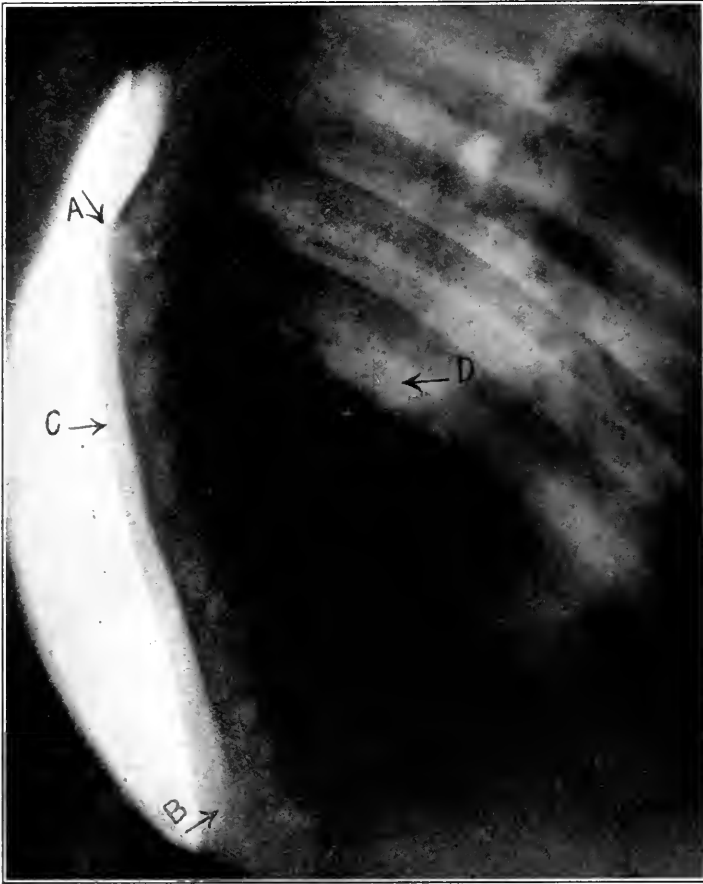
Roentgenogram, showing bone-graft fixation of spine for Pott's disease in case of a child aged five years. This case, seen by the author in consultation with T. Halsted Myers, proved to be one of the most acute cases of tuberculosis of the spine that the author has ever seen. The patient had been under the care of a very excellent orthopaedic surgeon who had not succeeded in controlling the symptoms by any known conservative means, such as plaster jackets, spinal braces, Bradford frames, etc. For some months the child had been immobilized by a well-fitted spinal brace (Taylor's), supplemented by recumbency in the dorsal position upon a Bradford frame. In spite of this most rigorous treatment, however, active symptoms had continued uncontrolled, with periodical attacks of violent vomiting which was apparently a reflex phenomenon resulting from the uncontrolled spinal condition. This seemed all the more certain after the more adequate spinal fixation by bone graft later, when the attacks of vomiting subsided entirely. The classical operation of Albee for the treatment of Pott's disease was performed by the author, the bone graft (indicated by arrows, A-B) being taken from the child's left tibia. Following operation, the patient made a very splendid convalescence, although the acuteness of the symptoms demanded great conservatism. The child was kept in the recumbent position in bed for about three months, followed by an application of a Taylor spinal brace which was worn for about six months. The child continued to improve, and is at present completely recovered, with splendid function of the spine, and without any deformity, as is indicated by the arrows, C-D, which designate the original site of the disease. He is an active boy aged eight years, who enjoys the same games, and is quite as energetic, as any of his playmates.
